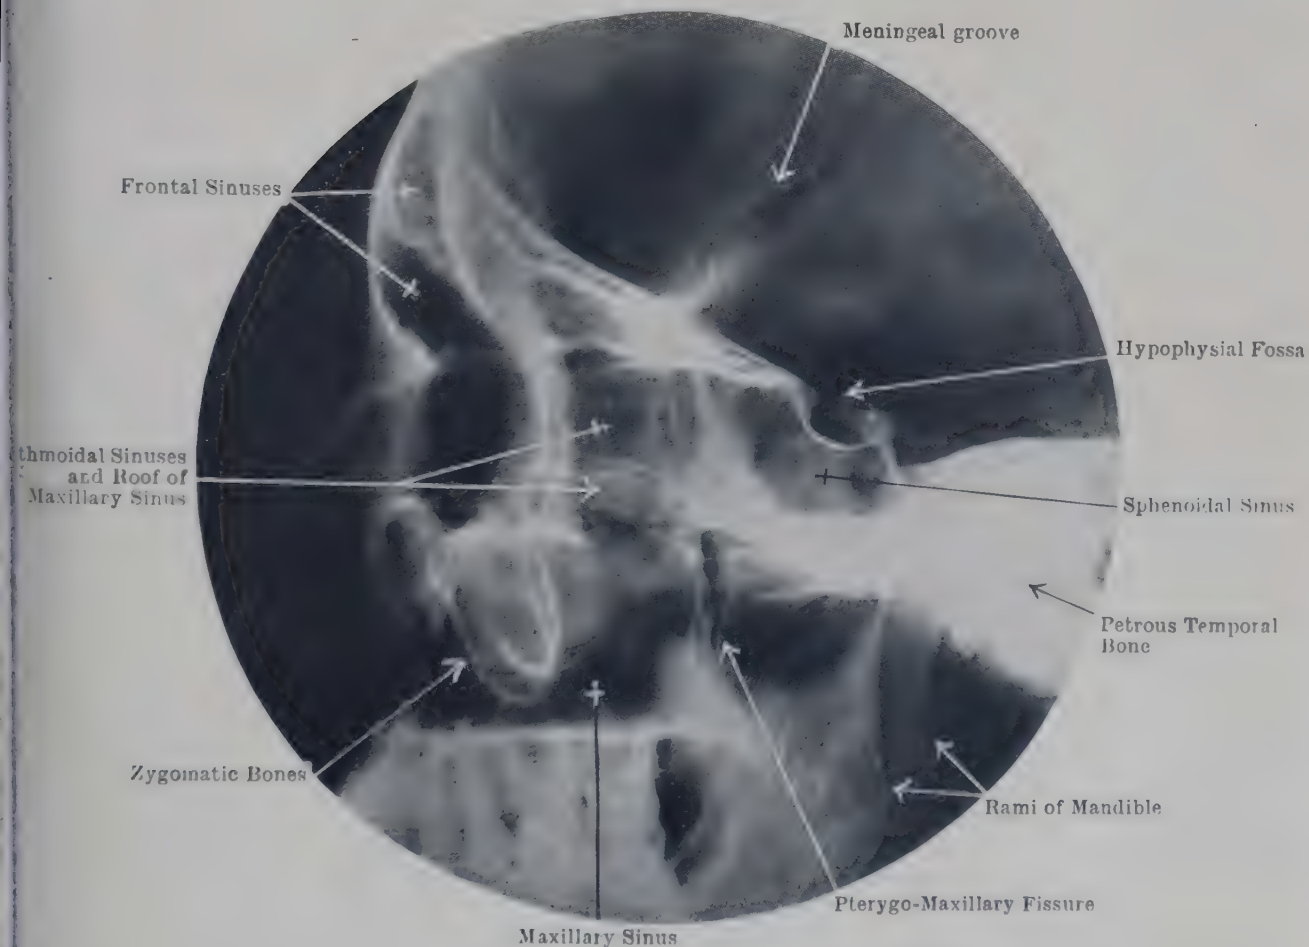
LATERAL RADIOGRAPH OF SKULL WITH SLIGHT TILT.
